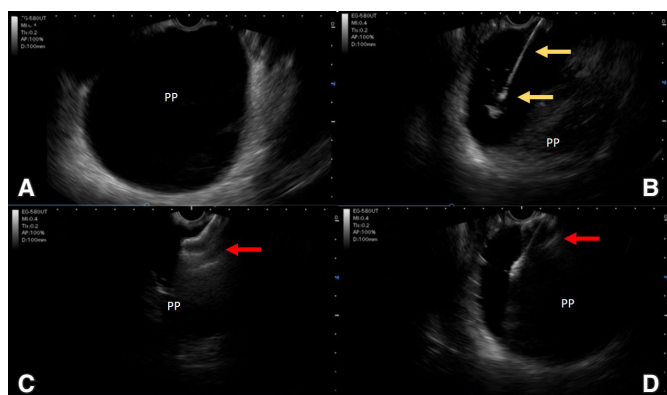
Endoscopic ultrasound. A. Image with an anechoic, oval area with precise limits - pancreatic pseudocyst (PP). B. Insertion of the HotAxios system into the pancreatic fluid collection (yellow arrows). C. Initial moment when the distal flange (red arrow) of the HotAxios prosthesis system was opening. D. Moment of traction against the PP wall of the distal flange (red arrow) to start opening the proximal flange in the gastric lumen.
